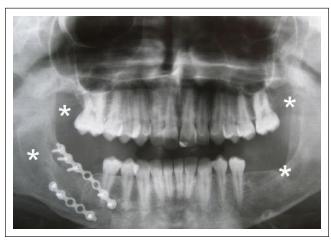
Panoramic radiograph after two years of surgical, bone repair. (asterisks).
